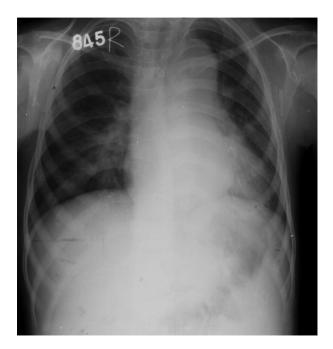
Chest radiograph in a 12-year-old girl showing prominent aortic knuckle causing mediastinal widening.
